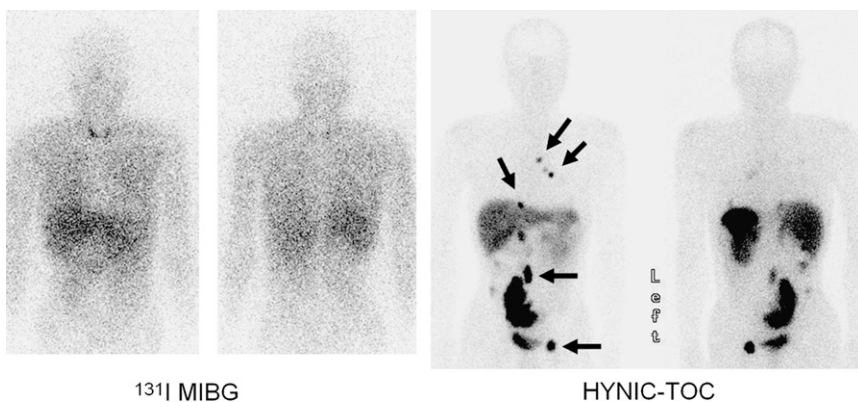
A 58-y-old man had pheochromocytoma 10 y ago, and the primary tumor had been successfully removed surgically. One year before patient underwent ^{131}I -MIBG imaging and $^{99\text{m}}\text{Tc}$ -HYNIC-TOC scintigraphy, groin pain had developed. ^{131}I -MIBG imaging did not reveal any abnormalities except for mildly increased activity in thyroid bed, which was attributed to unlabeled free ^{131}I . However, subsequent $^{99\text{m}}\text{Tc}$ -HYNIC-TOC scintigraphy demonstrated many foci of intense activity (arrows), indicating metastatic malignant pheochromocytomas, as confirmed by biopsy.
